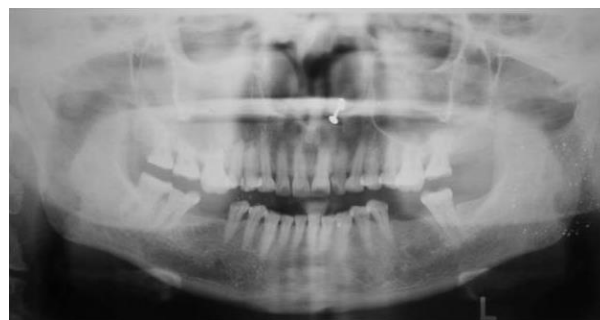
Panoramic Radiograph showed diffuse hazy uniform radiopacity in the right maxillary sinus and the floor of the sinus was unable to appreciate compared to the left side
